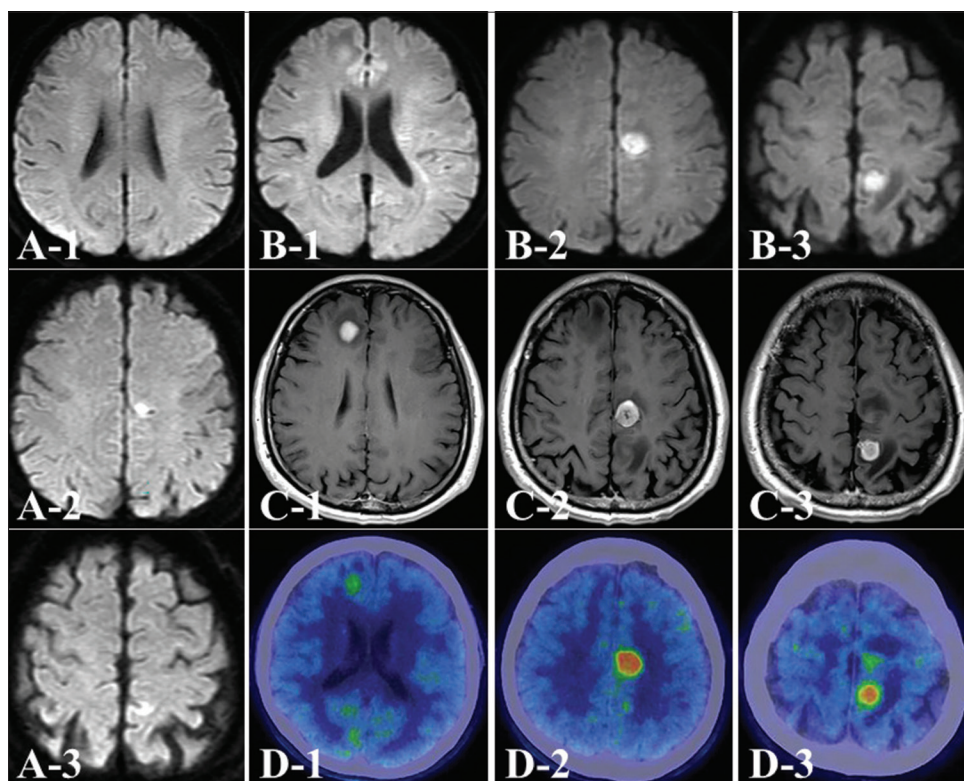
Preoperative axial diffusion-weighted image (DWI) on magnetic resonance imaging shows a high-intensity mass in the left hemisphere (a). These masses are rapidly growing, and a new lesion appears in the right frontal lobe (b). These tumors in accordance with the DWI high-intensity lesion are homogeneously enhanced to a high degree with gadolinium (c). The maximum standardized uptake values on methionine positron emission tomography are high (d).
